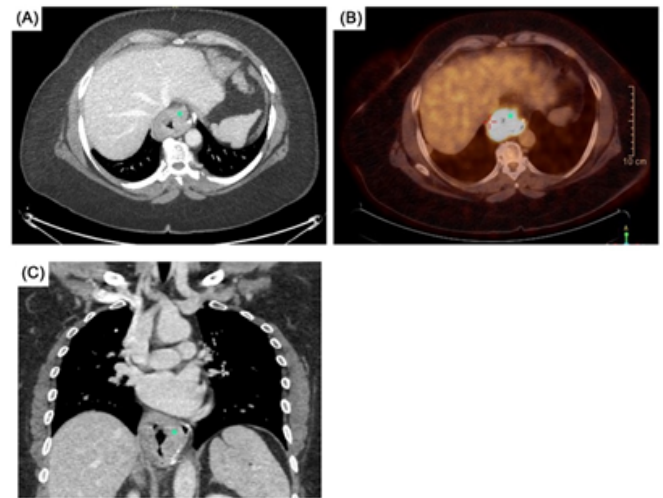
(A) Axial view of CT chest with asterisk showing the cancer, (B) PET-CT with asterisk showing the cancer with hypermetabolic activity, (C) Coronal view of CT chest with asterisk showing the cancer with hiatal hernia noted.).
